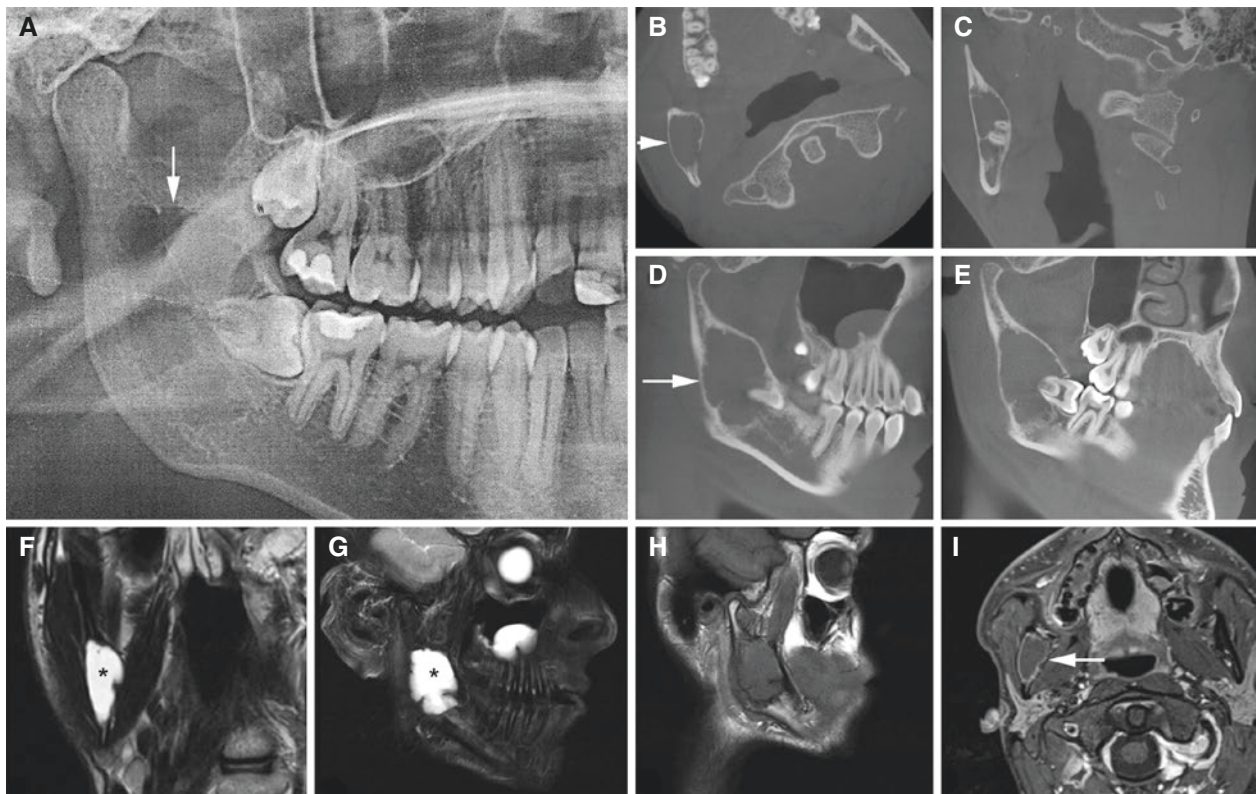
Simple bone cyst, mandible; 18-year-old male with incidental finding. (A) Panoramic view shows rather well-defined and slightly scalloped radiolucency in the right mandibular ramus (*arrow*) and impacted wisdom tooth. (B) Axial, (C) coronal, and (D, E) oblique sagittal CBCT images show lesion (*arrow*) with thinned, intact corticated outline, with some buccolingual expansion, and without root resorption. (F) Coronal
